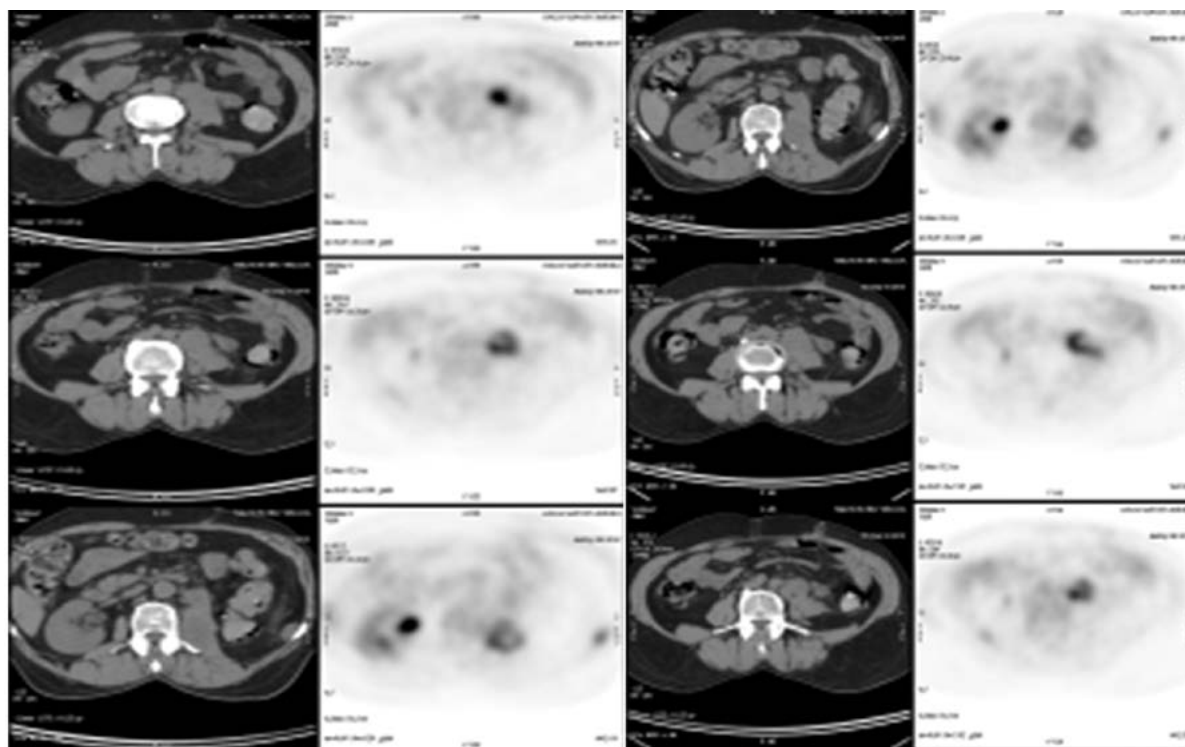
56-years-old male patient with RCC underwent left nephrectomy with suspected recurrence, FDG PET-CT showed active mass infiltrating the left psoas muscle with SUVmax ~6.5, lumbar peritoneal nodule with SUVmax ~4.5 and common iliac nodal deposits with SUVmax ~9.5
